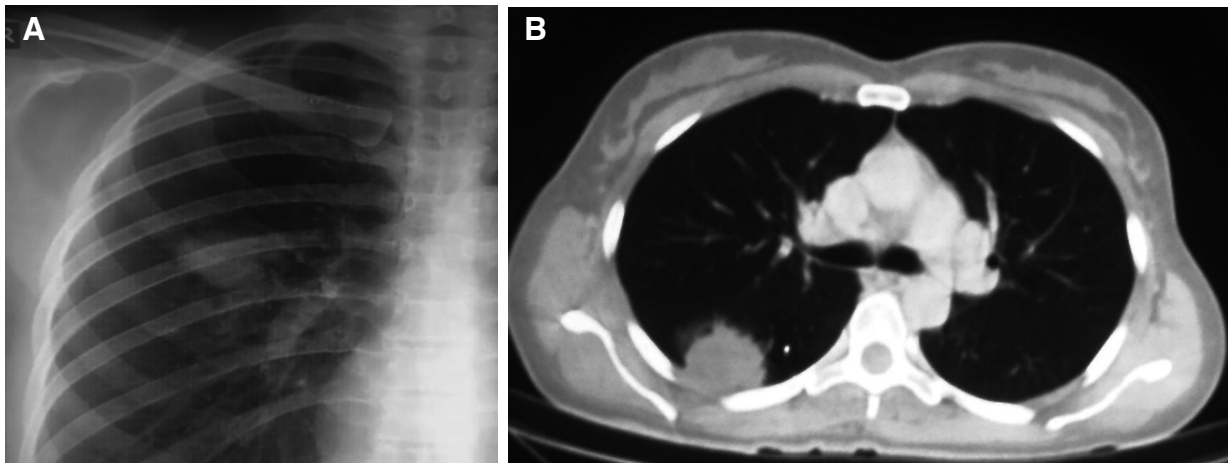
A. Chest X-ray shows a radiopaque lesion in the right upper lobe, and in image 1B, the chest CT scan reveals a rounded mass with spicules, located near the chest wall on the right side.
